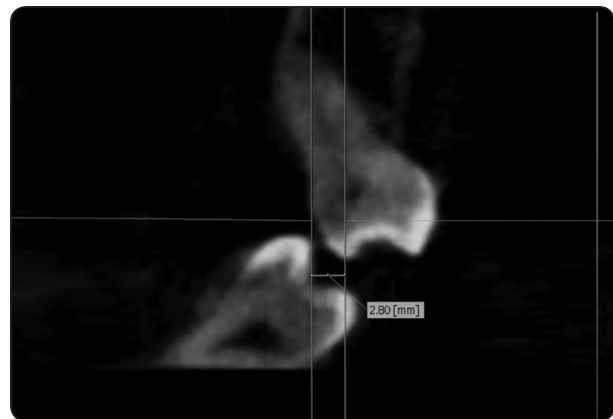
Coronal CBCT image of measurement of cross-bite at first premolars.
